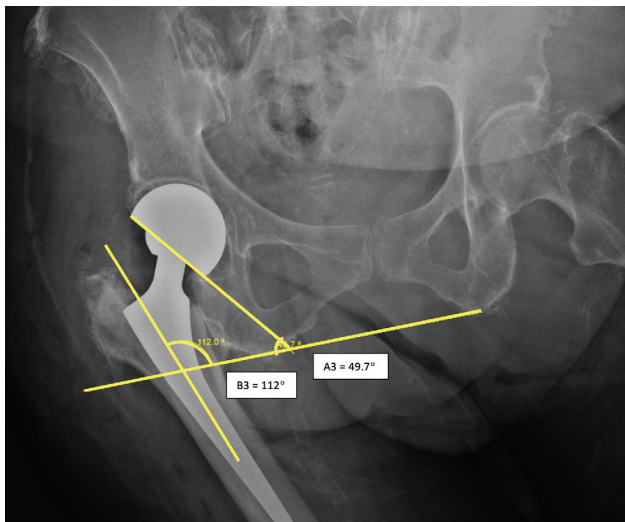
Hip maximum adduction AP x-ray.
